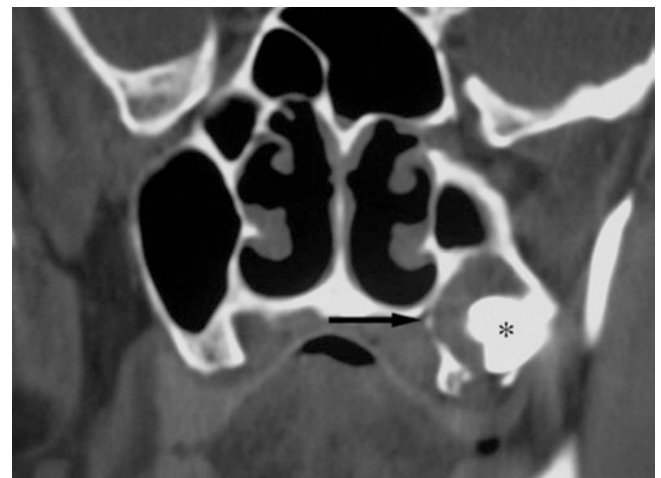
Follicular cyst, maxilla; 54-year-old male with incidental finding at paranasal sinus examination. Coronal CT image shows expansive process (*arrow*) around crown of impacted third molar (*asterisk*)
